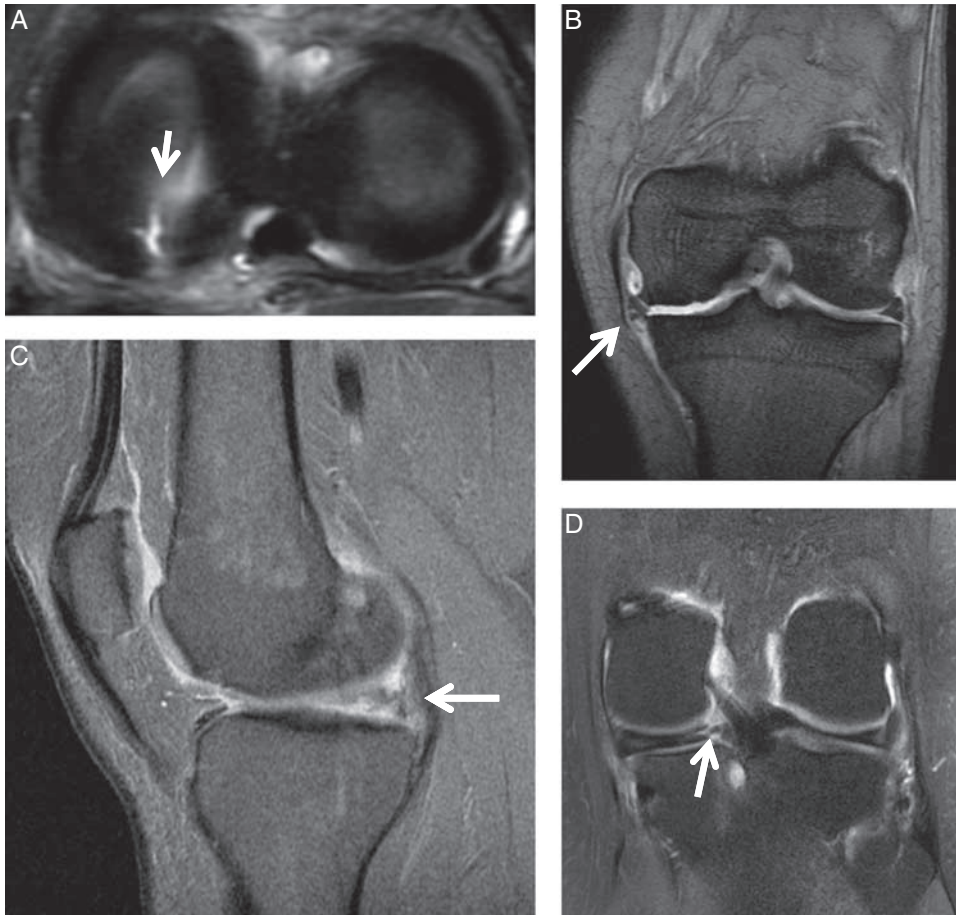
Magnetic resonance imaging findings suggestive of meniscus root injury include radial tear in the root (A), meniscal extrusion outside of the tibial plateau (B), increased signal/absent meniscus (ghost sign) (C), and vertical linear defect in the root (truncation sign) (D). Arrows point to described pathology.
